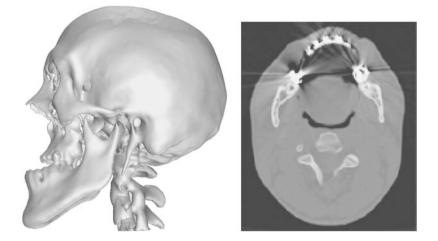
Left image: An isosurface of a CT image of a human skull shows a topological problem – upper and lower teeth are not separated. Right image: Metal artefacts in a CT image may severely distort the geometric information.
